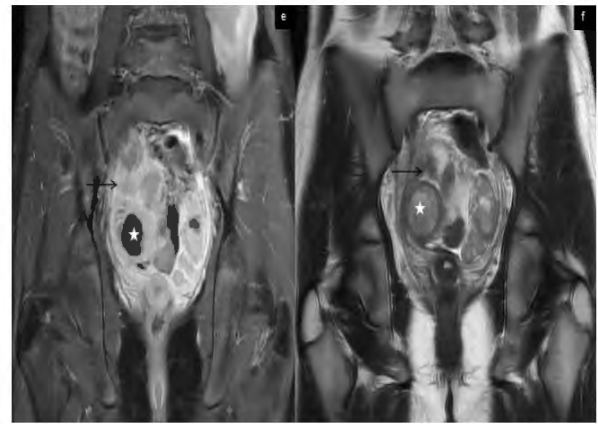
On axial T1-weighted (a), axial fat-saturated enhanced T1-weighted (b), axial T2-weighted (c), axial fat-saturated T2-weighted (d), coronal fat-saturated enhanced T1-weighted (e) and coronal T2-weighted (f) series; specific thickening on omentum and intense omental enhancement were present (black arrows). The ovaries were thickened, and surrounded by the omentum; heavily-contented and some hemorrhagic cysts were visualized in both ovaries (asterisk). The sizes of ovaries were increased. The free fluid was present in pelvic. It is considered that the increase at ovary sizes, and proteinosis-hemorrhagic containing cysts developed as secondary to disorder in vascularization. Urachal cyst was noticed adjacent to the left rectus abdominis muscle (white arrow).
